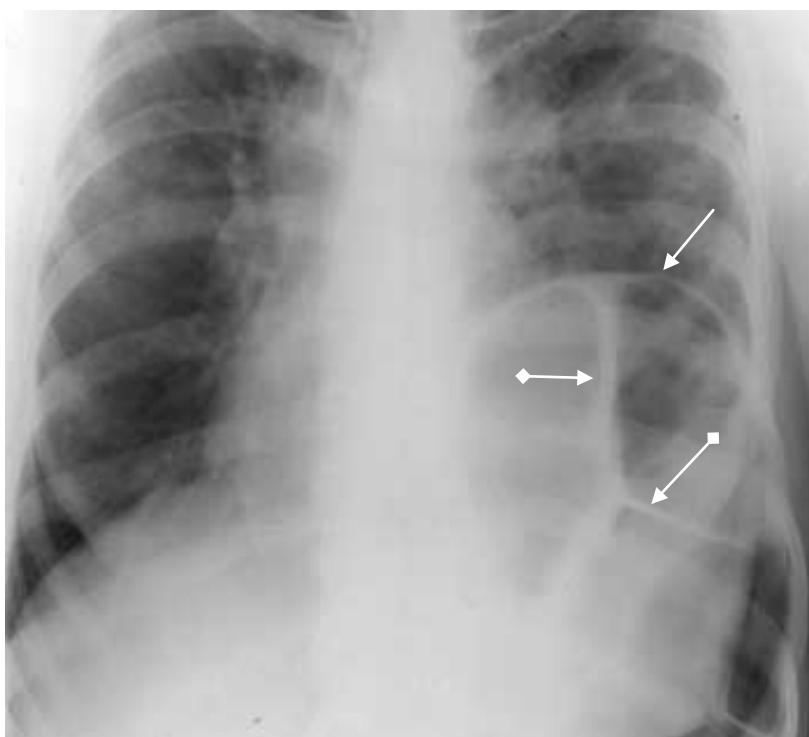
The anteroposterior chest radiograph. In the left pulmonary field a subtotal non-homogeneous shadow with the radiolucent zone (white arrow) divided by linear shadows (arrows with rhombs). Pulmonary vasculature in the left lung is prominent. Mediastinum is shifted to the right. The cupula of diaphragm on the left is not differentiated clearly. Diaphragmatic hernia at the left
